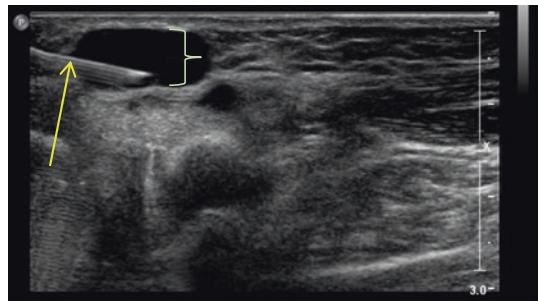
Ultrasound-guided aspiration ganglion cyst: image of US position
